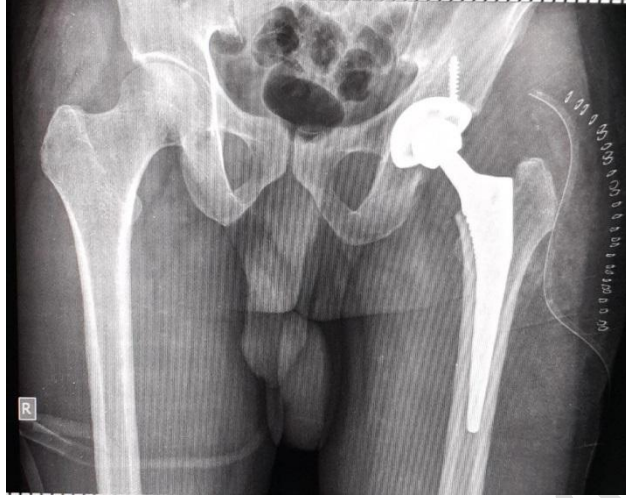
Post-op X-ray- Pelvis with both hips AP view: showing the THR implant in situ.
